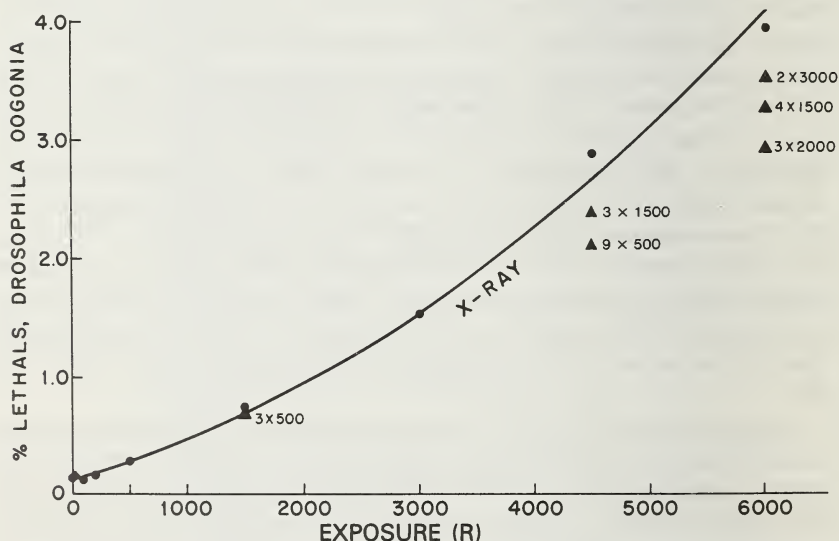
Drosophila* oögonial x-ray mutation rate data of Meyer and Abrahamson (1978). The solid circles represent single acute exposures and the solid triangles represent fractionated exposures as indicated on the figure.
